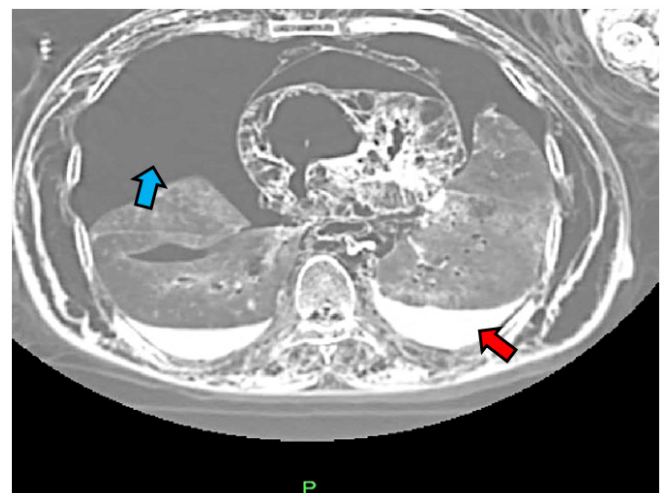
CT thorax showing the post-mortem fluid (red arrow) and gas (blue arrow)
